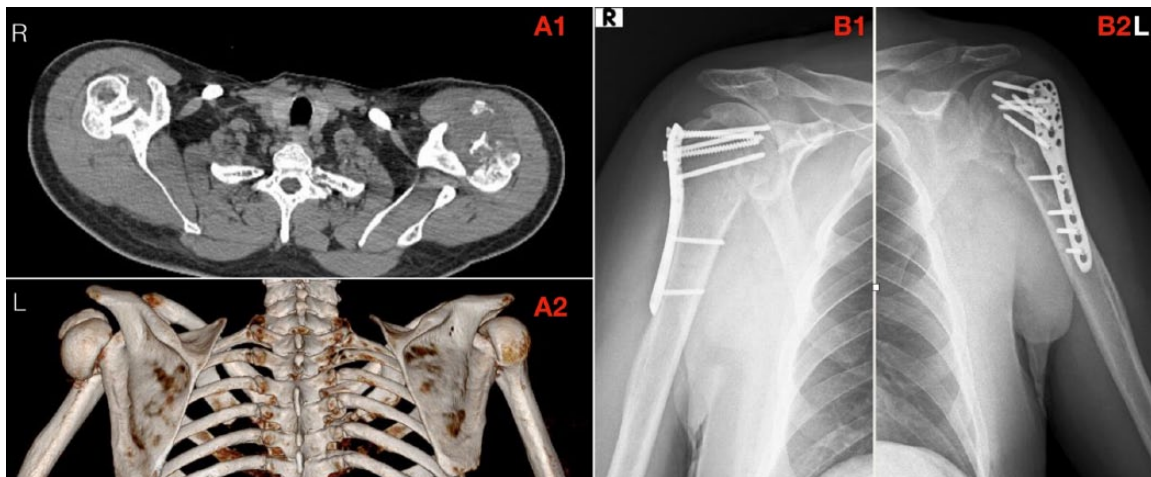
Pre-operative axial and three-dimensional tomography scans (A1, A2) and post-operative radiographs of the both shoulders at 24 months (B1, B2 / R, right; L, left) of a 37-year-old male who sustained an LPDS during a seizure and was treated at the fifth week after injury.
